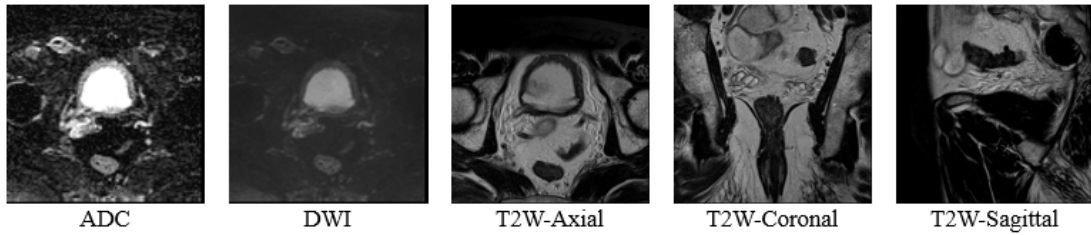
Examples of the MRI modalities utilized for cancer classification: ADC map, DWI, and T2W scans (axial, coronal, and sagittal views)*
